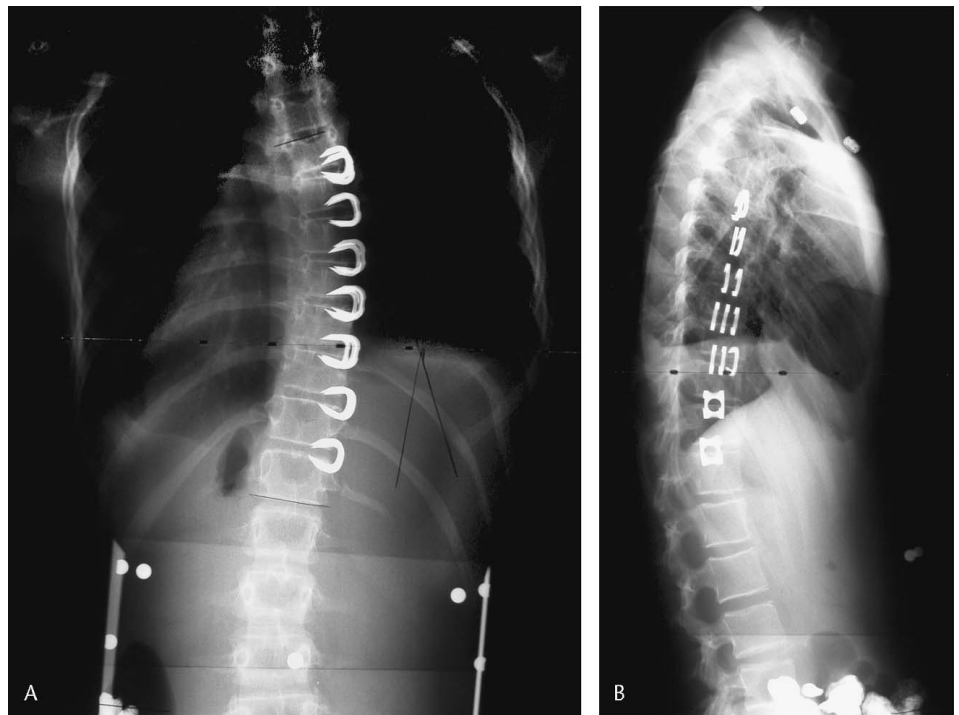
(A) A posterior-anterior and (B) a lateral erect radiograph of a 13-year-old who had stapling of a right thoracic curve with three staples crossing the vertebral body at the area of hypokyphosis are shown.
